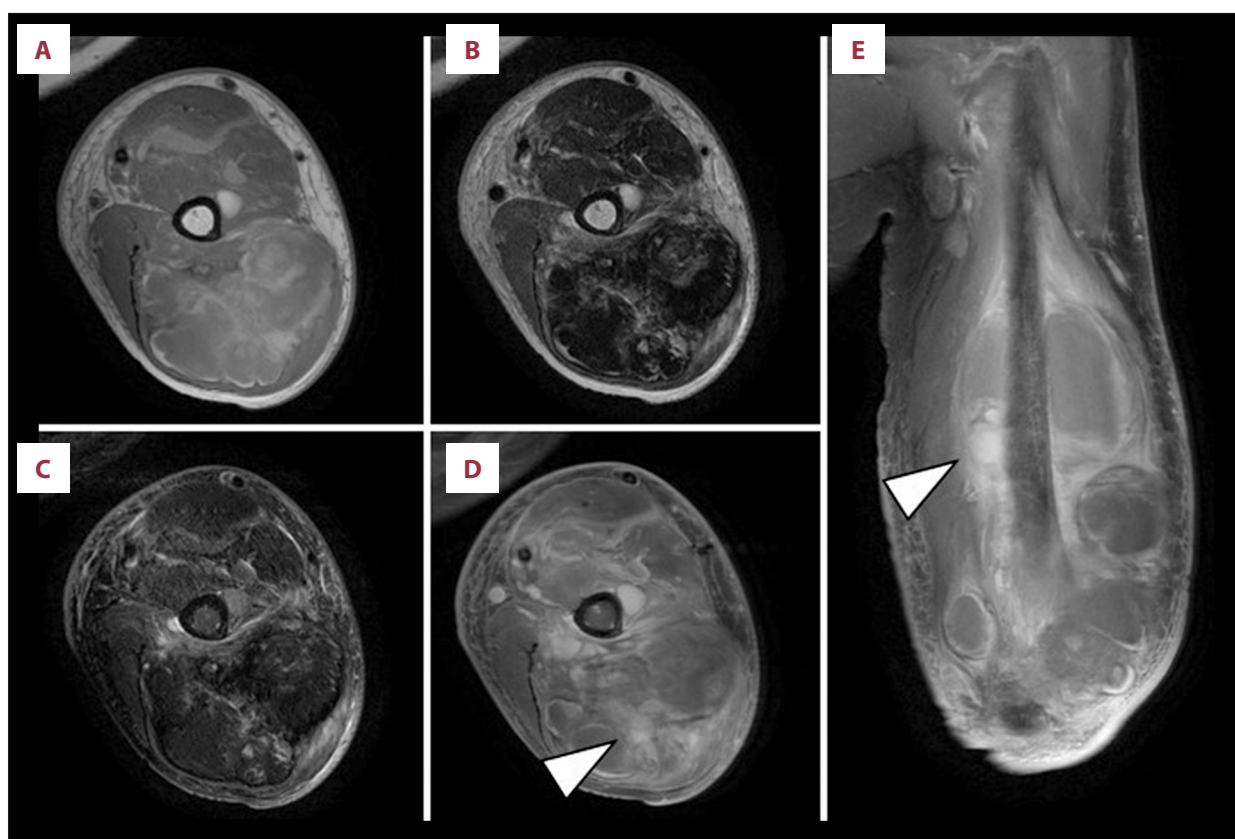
Magnetic resonance imaging (MRI) findings at the initial presentation. MRI shows a multilocular lesion measuring $16.1 \times 8.1 \times 5.3$ cm, mainly within the left triceps brachii muscle, extending to the flexor and extensor aspects of the upper arm. The lesion has iso- to high-signal intensity on T1-weighted images (A, axial) and peripheral high-signal intensity with internal low-signal intensity on T2-weighted images (B, axial). On short tau inversion recovery (STIR) images, the internal low-signal components are more clearly delineated (C, axial). Gadolinium-enhanced MRI shows heterogeneous enhancement in part of the lesion (arrowheads) (D, axial; E, coronal).
